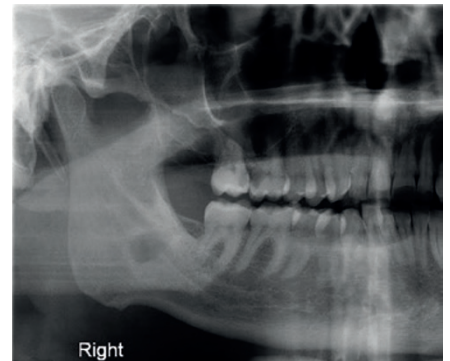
A sectional orthopantomogram
